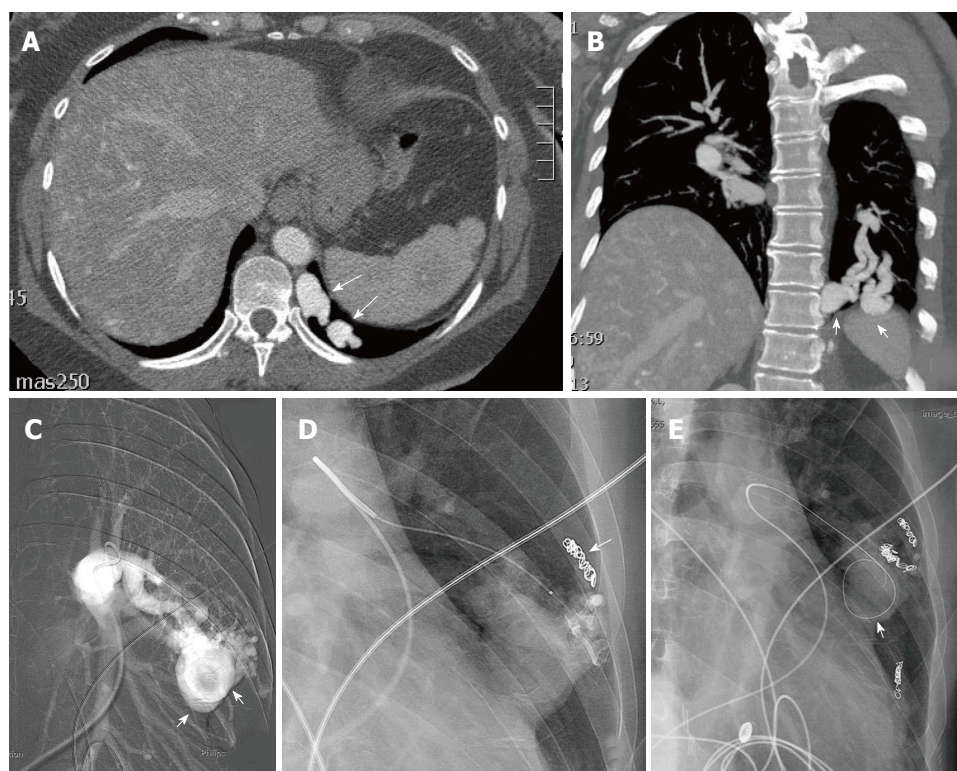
This patient with hereditary hemorrhagic telangiectasia presented with an abnormal chest radiograph. A computed tomography angiogram was performed for further evaluation. Axial CTA demonstrates a left lower lobe high flow vascular malformation (arrows) (A). Coronal reconstruction demonstrates several branches of the left lower lobe pulmonary artery feeding the malformation (arrows) (B). Sequential coil embolization of pulmonary arterial branches feeding the malformation was performed (arrow) (C). A framing coil was then placed in the venous aneurysm (D) followed by coil occlusion of the venous aneurysm and each of the remaining pulmonary arterial feeding branches (arrow) (E).
